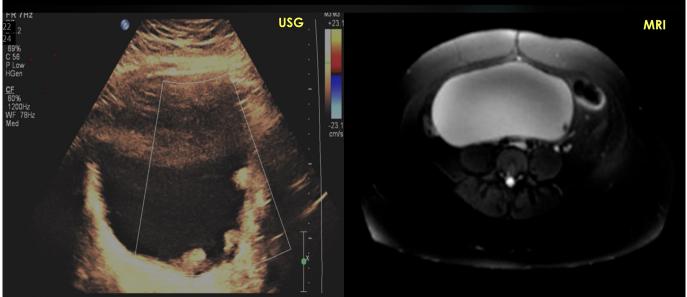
Case 1—Thick walled predominantly anechoic right adnexal mass with multiple mural nodules and mild vascularity on USG. USG: Ultrasound Sonography.
